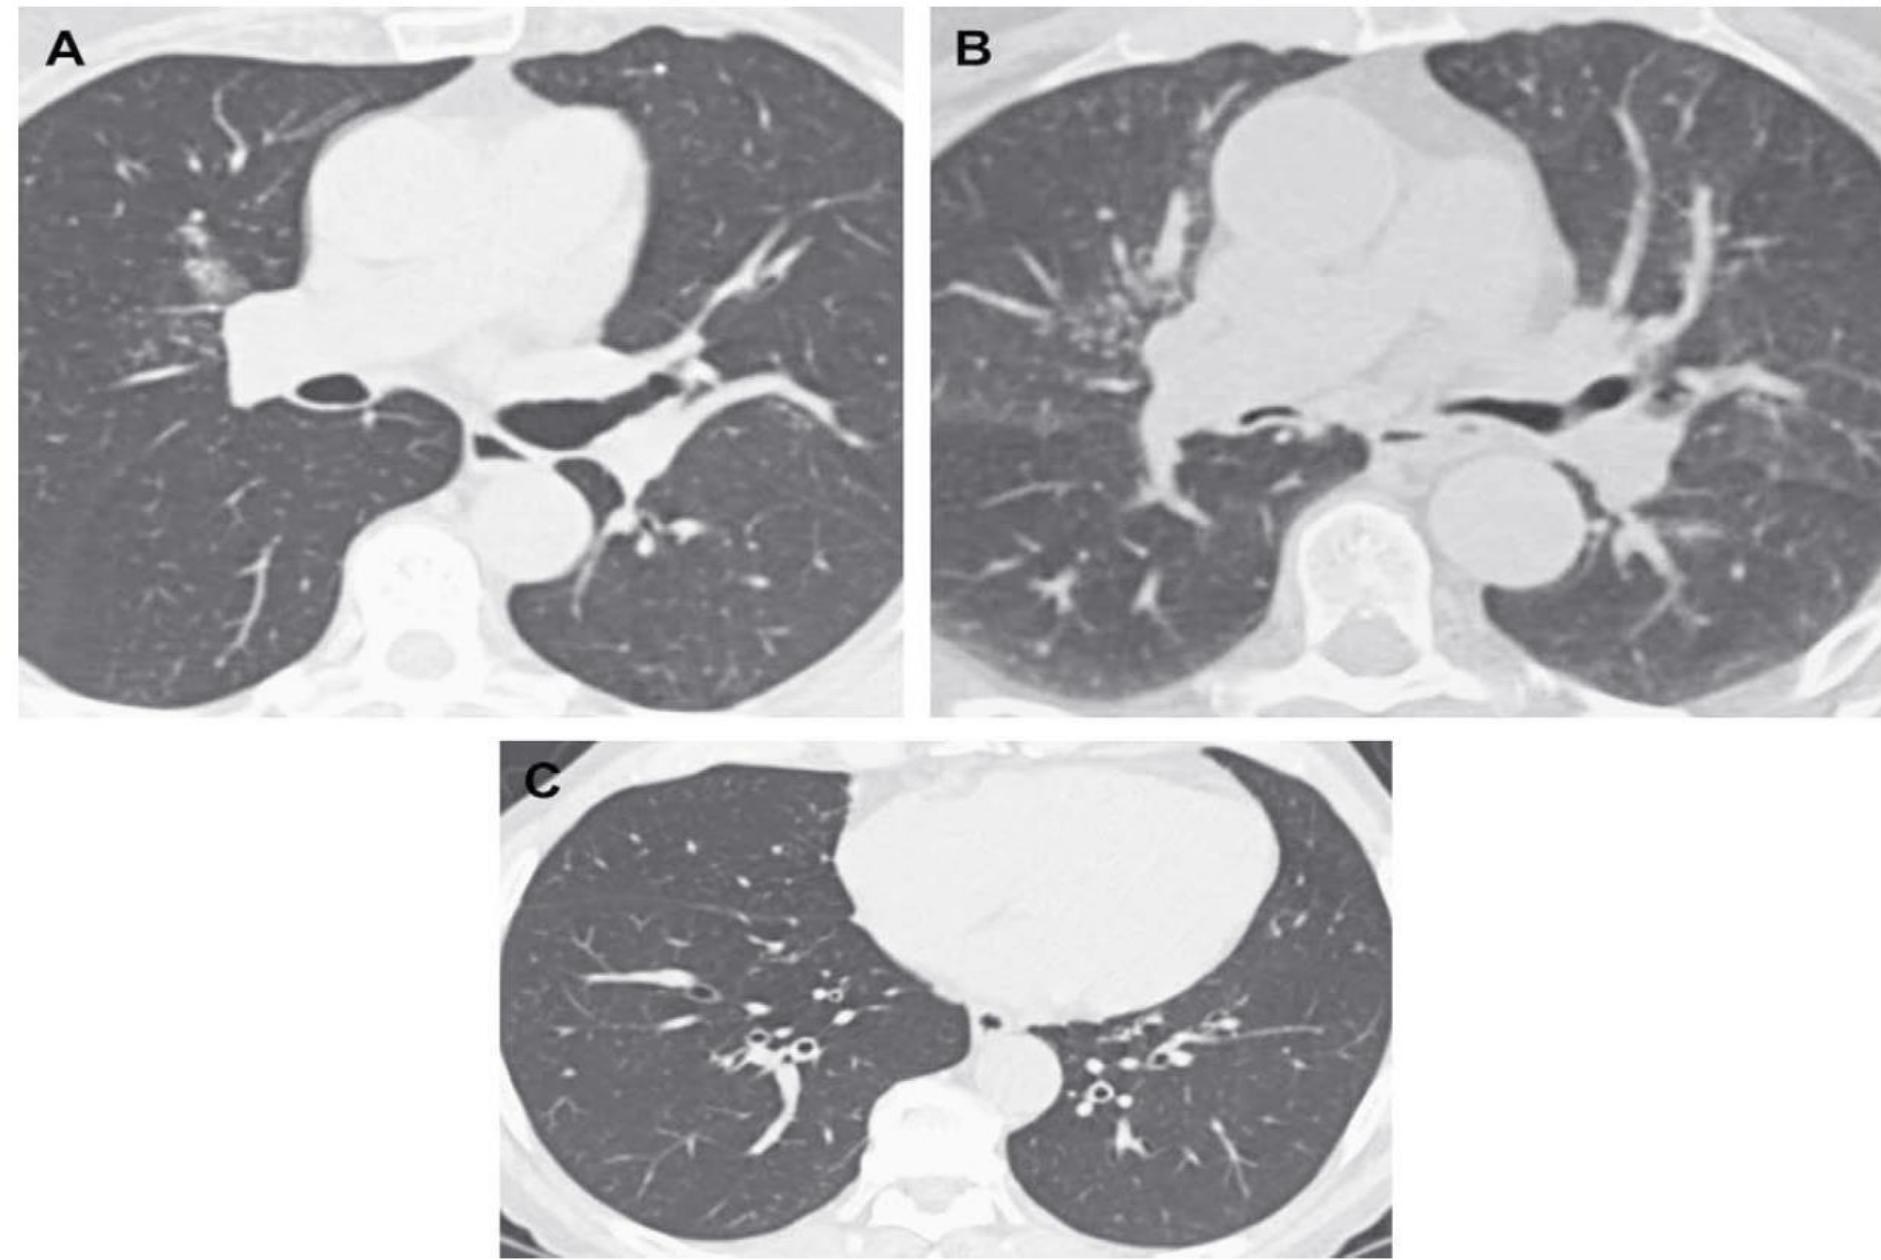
Bronchomalacia and bronchiectasis: a 68-year-old man with a reported history of asthma nonresponsive to steroid therapy. CT images show a normal caliber of the central bronchi (A), and marked collapse of their lumina when imaged during forced exhalation (B), consistent with bronchomalacia. The distal bronchi are diffusely dilated and have smooth wall thickening, consistent with miRadiol Clin N Am 47 (2009) 289–306
